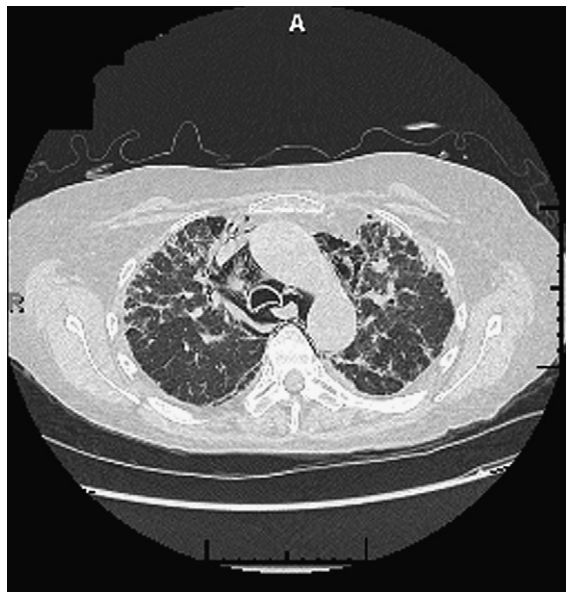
CT revealing air tracking around the bronchovascular bundle and pericardium along with honeycombing.
